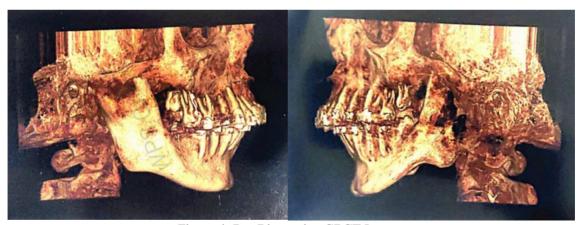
Pre-Distraction CBCT Images
